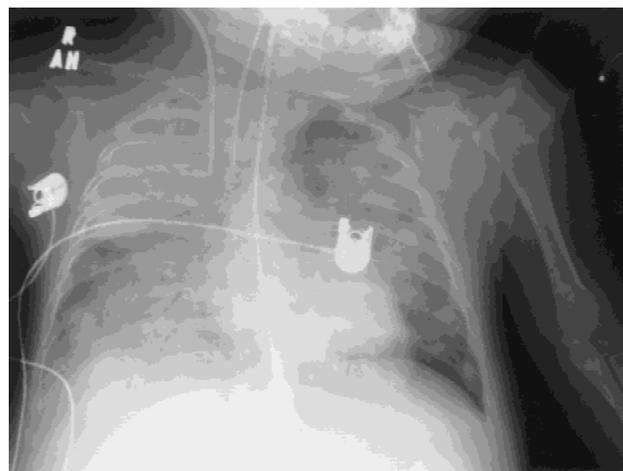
Chest radiograph, showing bilateral consolidation with air bronchograms consistent with severe pneumonia.
